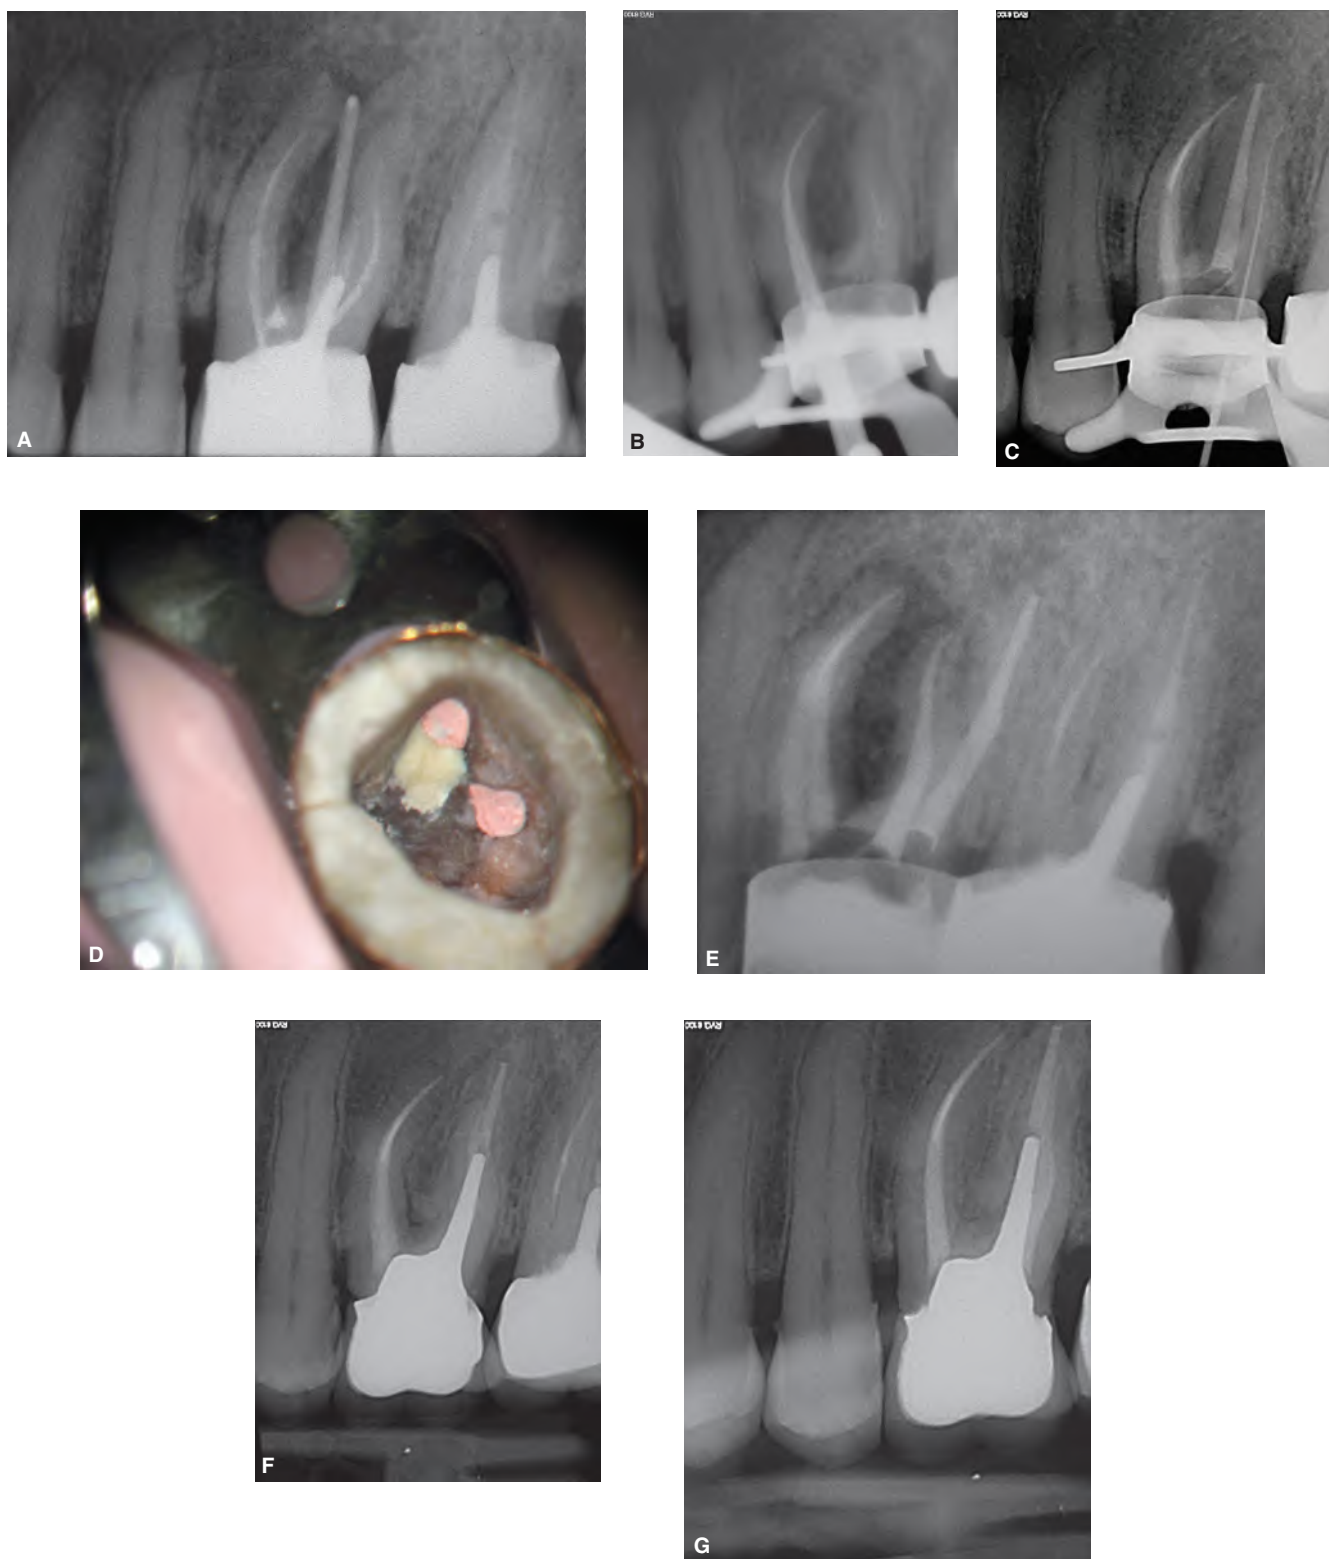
A. Preoperative radiograph showing a large intraradicular lesion and a sinus tract associated with the maxillary left first molar. A two-millimeter perforation of the inner wall of the MB canal was present below the orifice. B. After shaping of the MB-1 and MB-2 canals, the gutta-percha points serve as a matrix for placement of Biodentine to repair the defect. Note the separated instrument in the DB canal. C. After Biodentine setting, the gutta-percha points were removed and the mesial canals obturated. The DB canal was negotiated after removal of the broken instrument. Note the lower radio-opacity of Biodentine as compared to gutta-percha. D. A photograph of the pulp chamber showing repair of the perforation. E. Postoperative radiograph after completion of the treatment. F. One-year recall radiograph showing evidence of healing of the intra-radicular lesion. G. Two-year recall radiograph showing evidence of complete healing and formation of a new periodontal ligament in the furcation area.
